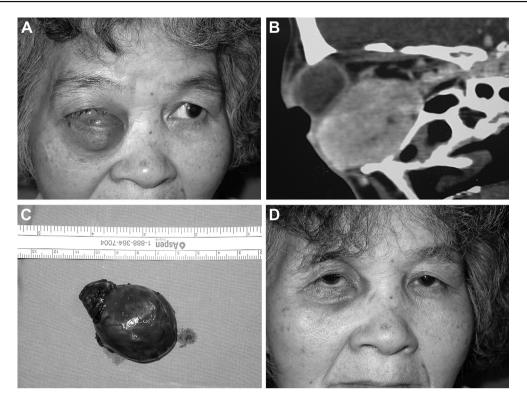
Case 4. (A) Facial appearance at initial examination reveals a protruding mass with severe displacement of globe and marked strabismus. (B) Sagittal computed tomographic image shows well-enhanced heterogeneous soft-tissue mass in the inferior orbit. (C) A well-circumscribed tumor measuring $5 \times 3.5 \times 1.5$ cm³. (D) Good prognosis after surgical treatment and adjuvant radiotherapy.
